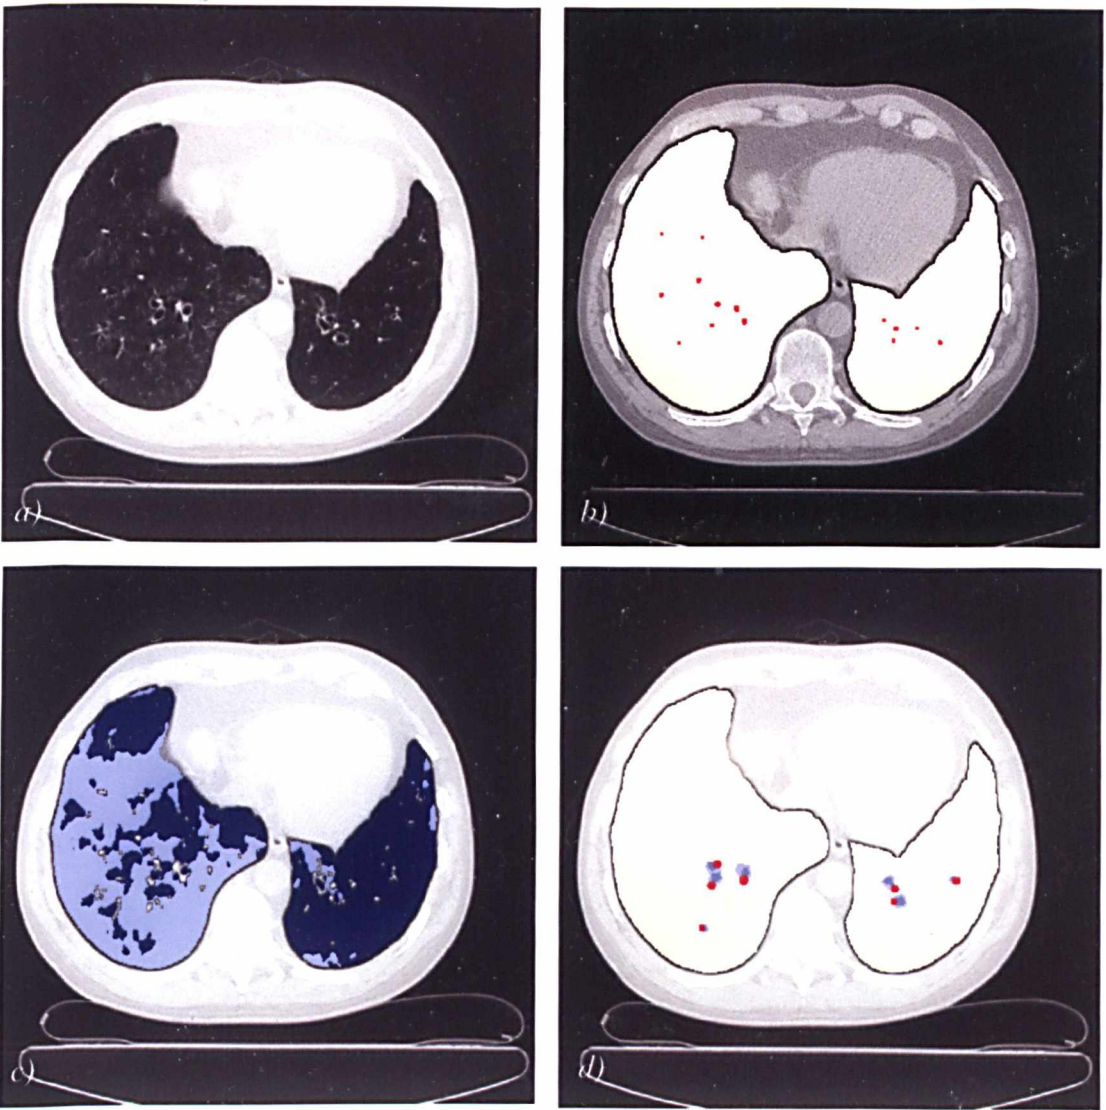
Example of the application of several features extractors to an image, in order to reach diagnostic conclusion. *a)* Cross-sectional image of the chest acquired with High-Resolution Computed Tomography (HRCT). *b)* Automated segmentation of the macroscopic pulmonary vessels, shown in red. The scarcity of vessels, particularly in the left lung (shown on the *right* of the image) suggests that perfusion is abnormally low. *c)* The automated segmentation of the areas of hypo-attenuation of the lung parenchyma (shown in dark blue) supports this hypothesis. The classifier based on CT densities reveals local inhomogeneities, referred to as mosaic attenuation pattern, and identifies 49 % of the lungs as hypo-attenuated. This pattern may be caused by an airways or vascular disease. *d)* Automated detection of the major perpendicular bronchovascular bundles. Each bronchus is displayed as blue and its accompanying pulmonary artery as red. The abnormally high ratio of bronchial/arterial diameters is evidence of severe bronchial dilatation and supports the diagnostic hypothesis of an airways disease as opposed to a vascular cause to the mosaic attenuation pattern.
